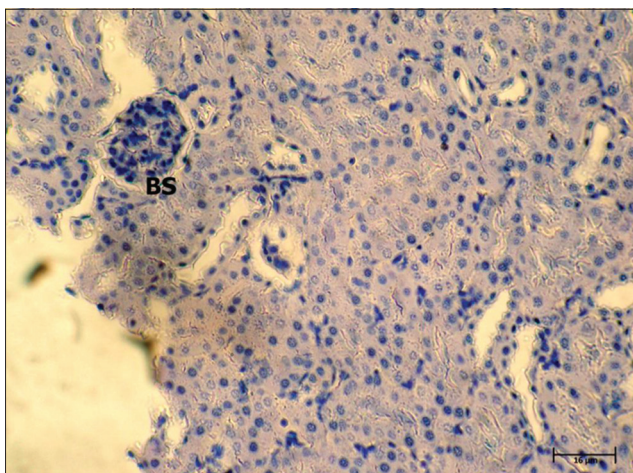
Kidney of *Mus musculus* fed with normal diet with the addition of silymarin. CT are cloudy. Normal glomerulus is present manifested by the BS although it is a bit narrowed. BS: Bowman's space, CT: Convoluted tubules
